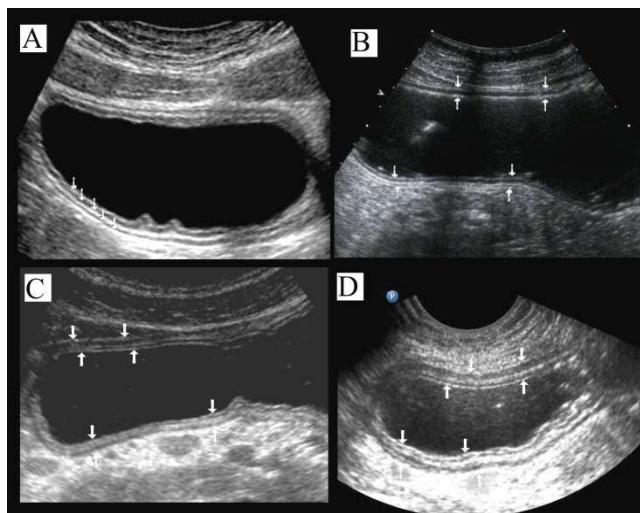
Ultrasonogram of the stomach for various projections of scanning and degree of filling. A – the arrows show all layers of the stomach wall at the body level in the transverse section; B - at the level of the small and greater curvature in the longitudinal section; C - at the antrum; D - with partial emptying. All layers of the stomach wall are clearly differentiated.
